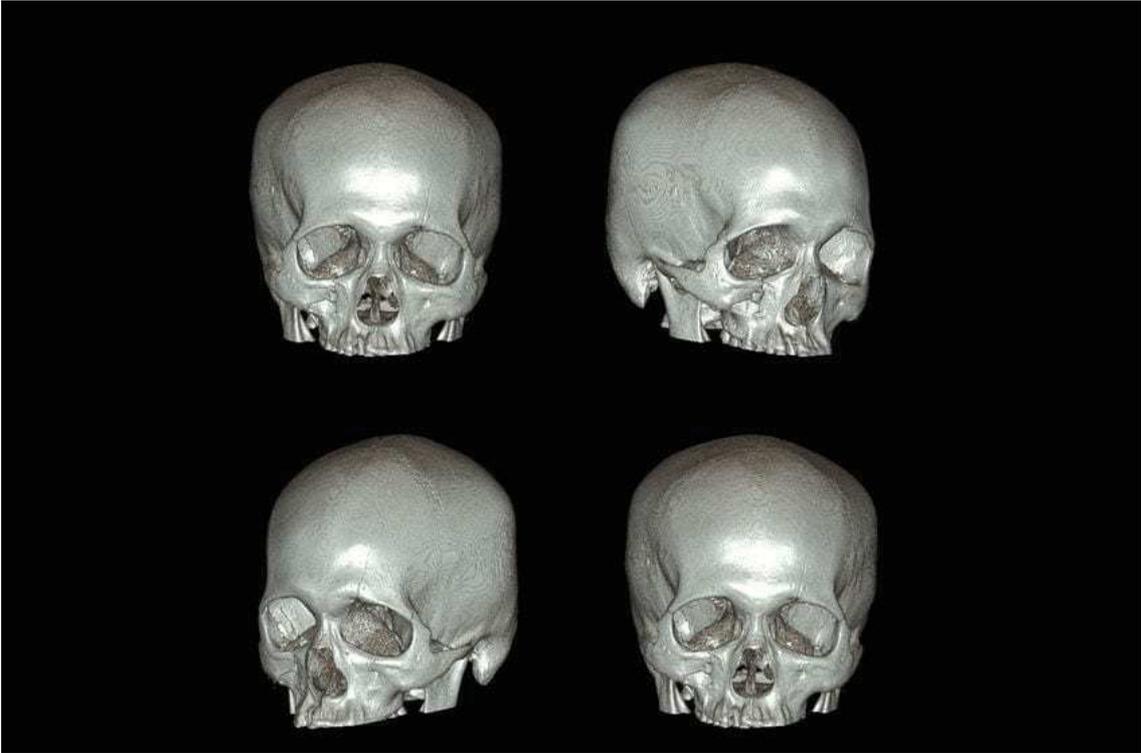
3D Computed tomography
